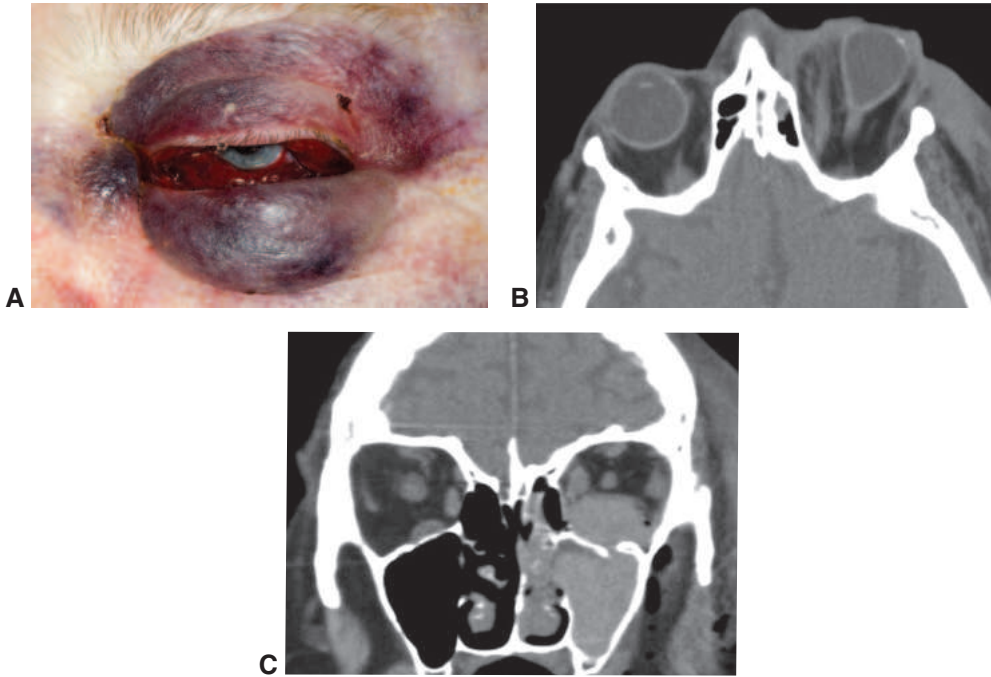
Orbital compartment syndrome (OCS). A, External photograph shows tense proptosis and bullous hemorrhagic chemosis. B, Coronal CT image shows globe tenting suggestive of stretch optic neuropathy. C, Axial CT image shows left orbital floor fracture with extensive intraorbital and maxillary sinus hemorrhage. (Courtesy of Steven M. Couch, MD.)
